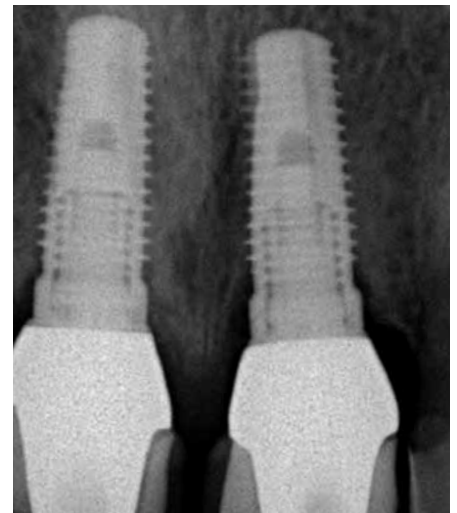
Final radiograph 2010.
